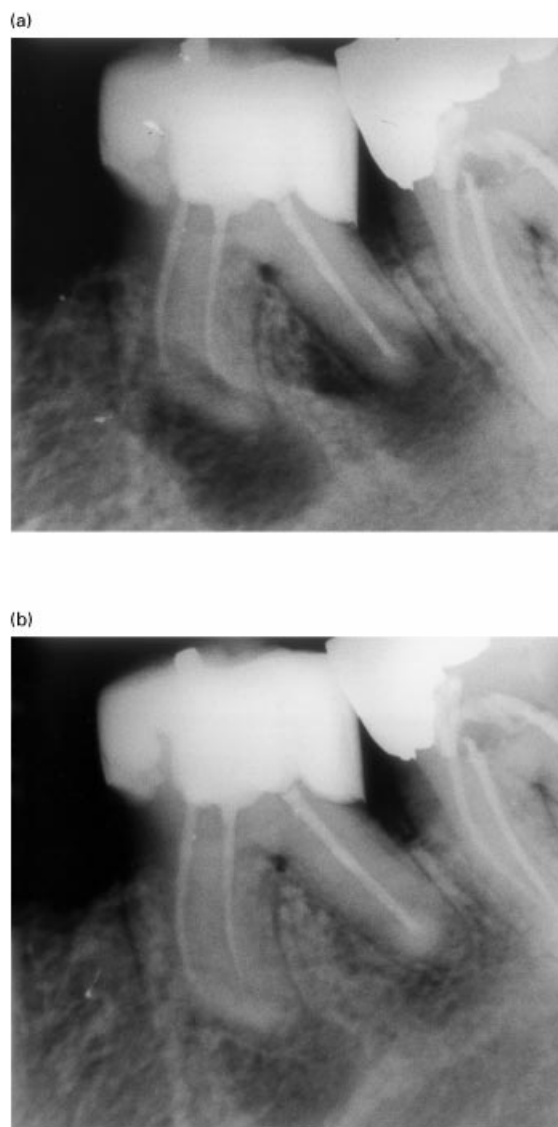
Formation of a periapical ligament space and lamina dura in a mandibular molar indicating complete healing. Reformation of cortical bone may occur later. Fifty-three-year-old male. a) preoperatively; b) one-year follow-up.
